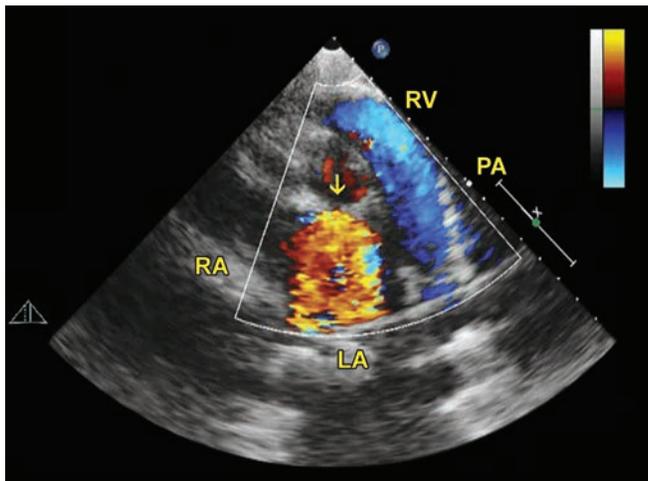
Color Doppler examination. Short axis view showing severe MR through the perforation (arrow) in the anterior MV leaflet.
